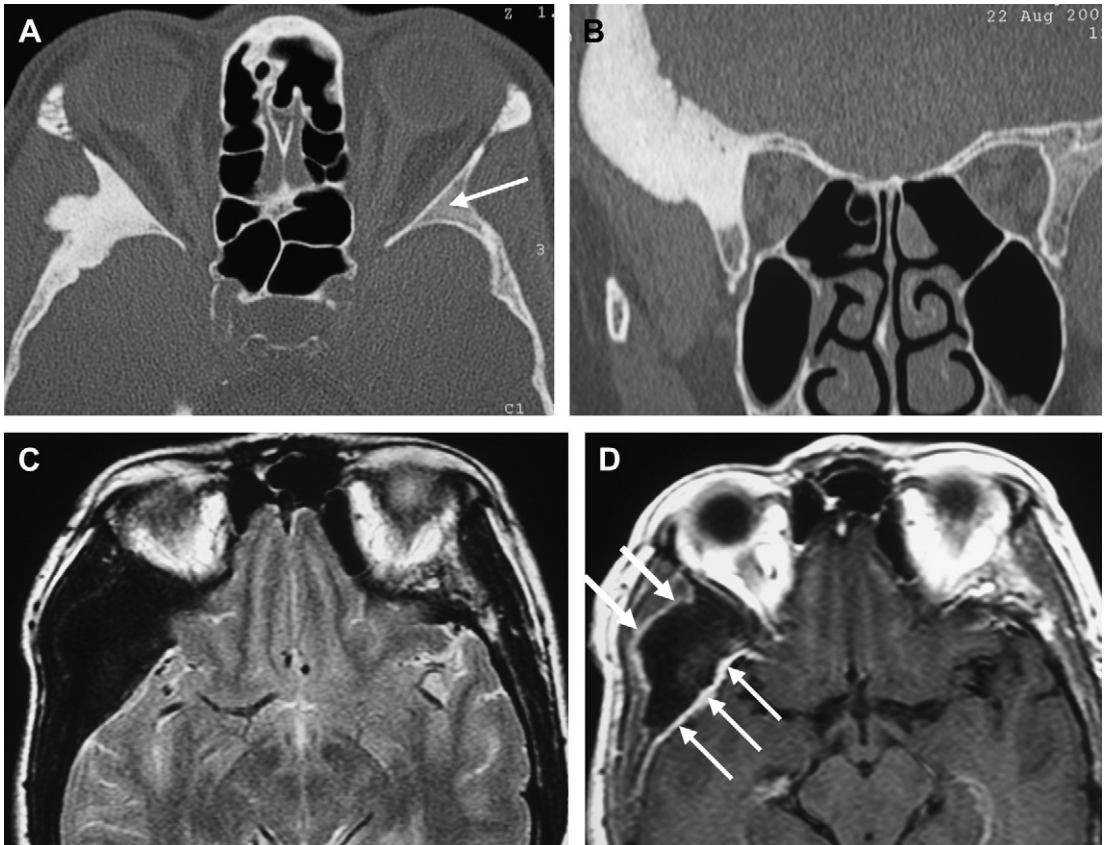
(A, B) Axial and coronal CT images in a bone algorithm demonstrate an expansile sclerotic lesion in the lateral CSB involving the sphenoid triangle and lateral orbital wall, bulging medially into the middle cranial fossa and laterally into the suprazygomatic masticator space (note the sphenoid triangle on the normal side- *white arrow*). On the axial T2-weighted image (C), the lesion follows the signal intensity of compact bone (signal void), and on the postgadolinium axial T1-weighted image (D), it shows only peripheral enhancement (*white arrows*) (intradiploic meningioma).
